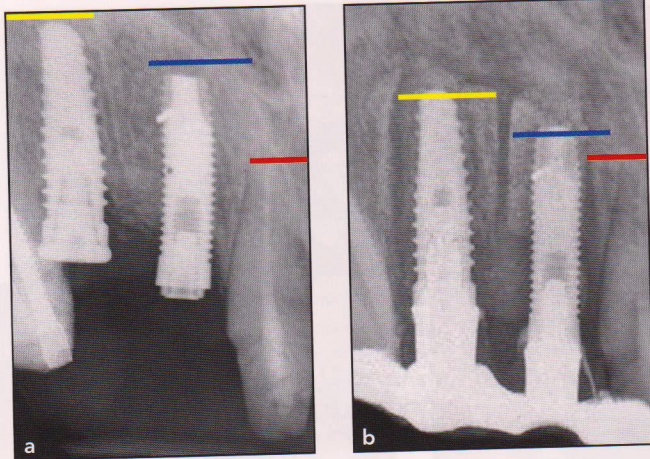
Periapical radiographs (a) before treatment and (b) at the 30-day healing period. It is possible to appreciate the coronal positioning of both segments (blue and yellow lines) compared to the apex of the maxillary right central incisor (red line).
